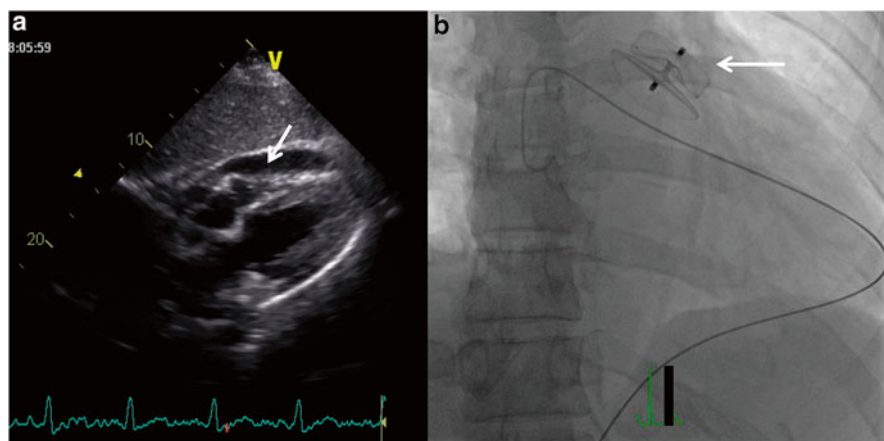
Delayed presentation with pericardial effusion in a 45 year-old female, 1 month following combined atrial fibrillation ablation procedure and left atrial appendage closure using ACP device. (a) Subxiphoid transthoracic echocardiographic window showing circumferential effusion (arrow) that is amenable to a subxiphoid approach to pericardiocentesis. (b) Fluoroscopic image showing typical appearance of 0.035" wire in pericardial space. ACP device indicated by white arrow
